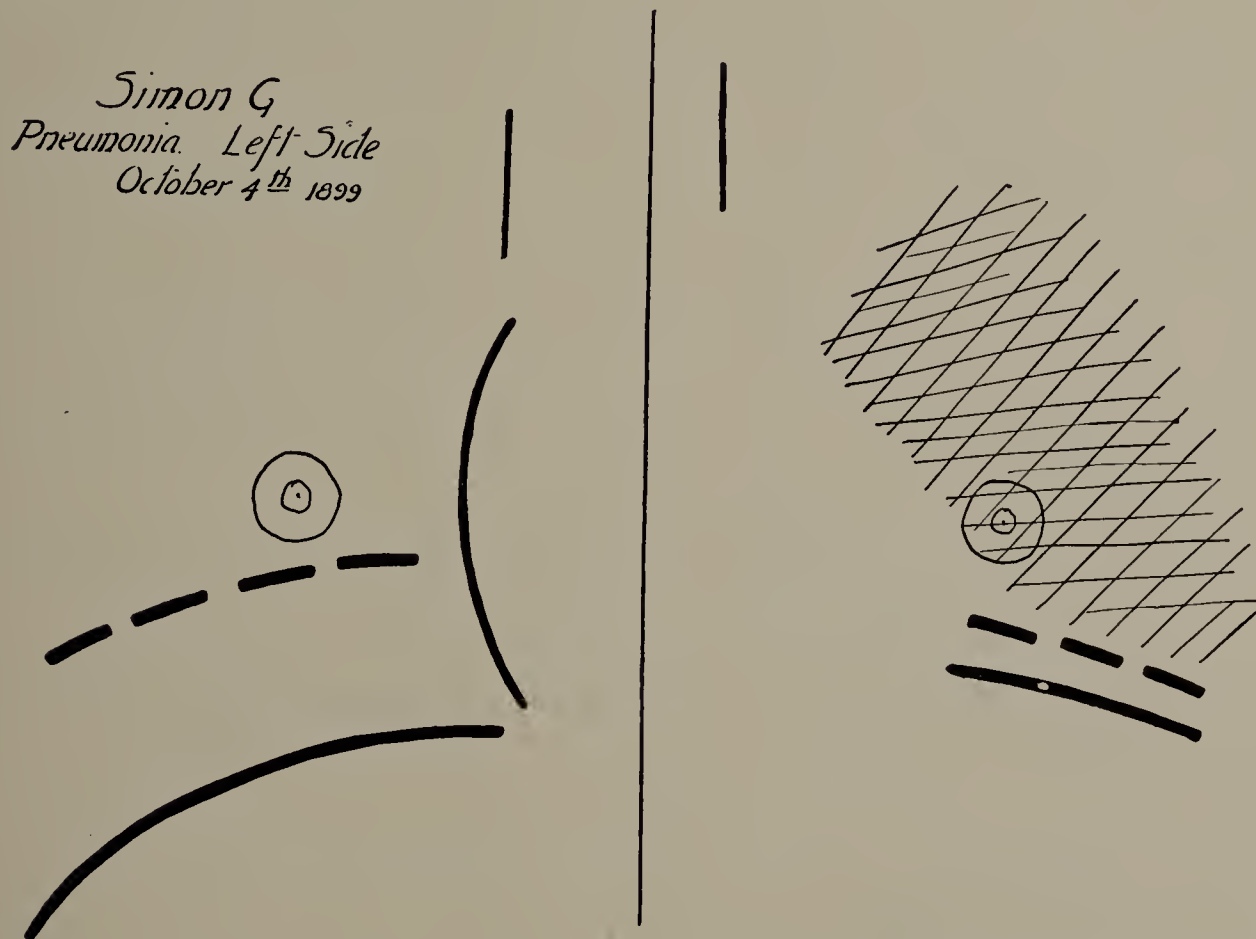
Simon G. Oct. 4, 1899. Cut of first X-ray tracing. Pneumonic process in left chest. Shaded left lung and restricted movement of left diaphragm. X-rays indicated that there had been some pneumonia on right side also, as shown by shortened excursion of diaphragm; but it was not detected by physical signs. (One-third life size.)
